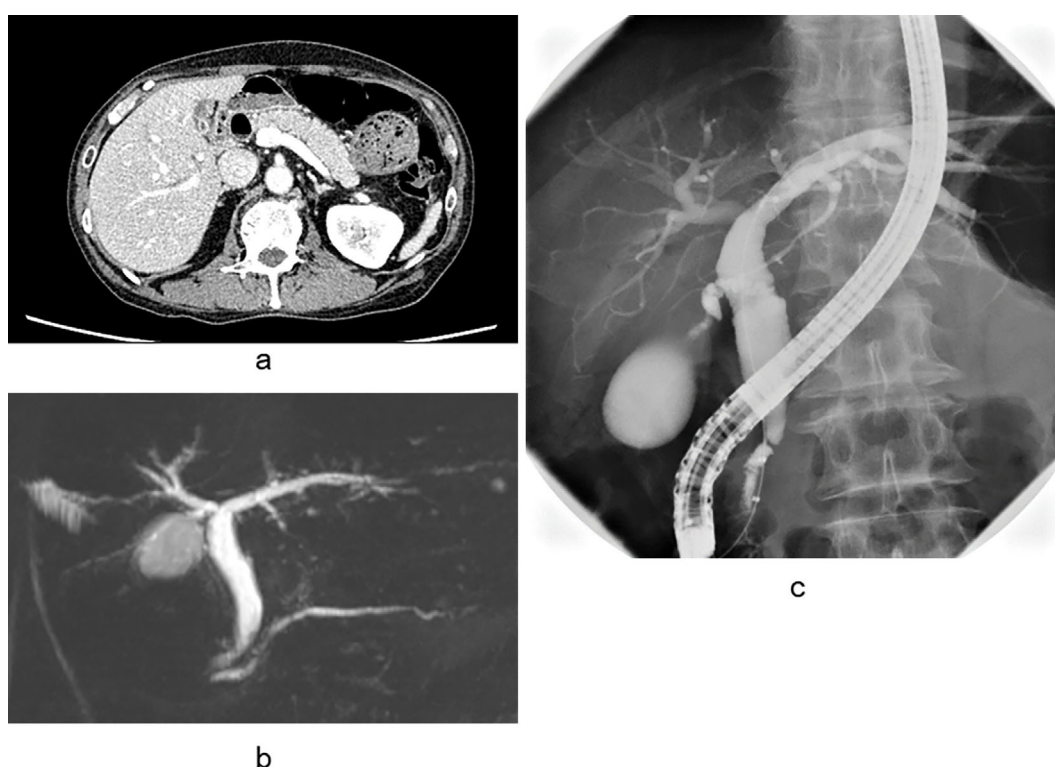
Images obtained with the re-escalation of the prednisolone dose. (a) CT shows a shrinking pancreas without dilation of the pancreatic duct. (b) MRCP and (c) ERCP show the marked improvement of distal stricture of the common bile duct and multiple sclerotic changes of the intrahepatic bile.
